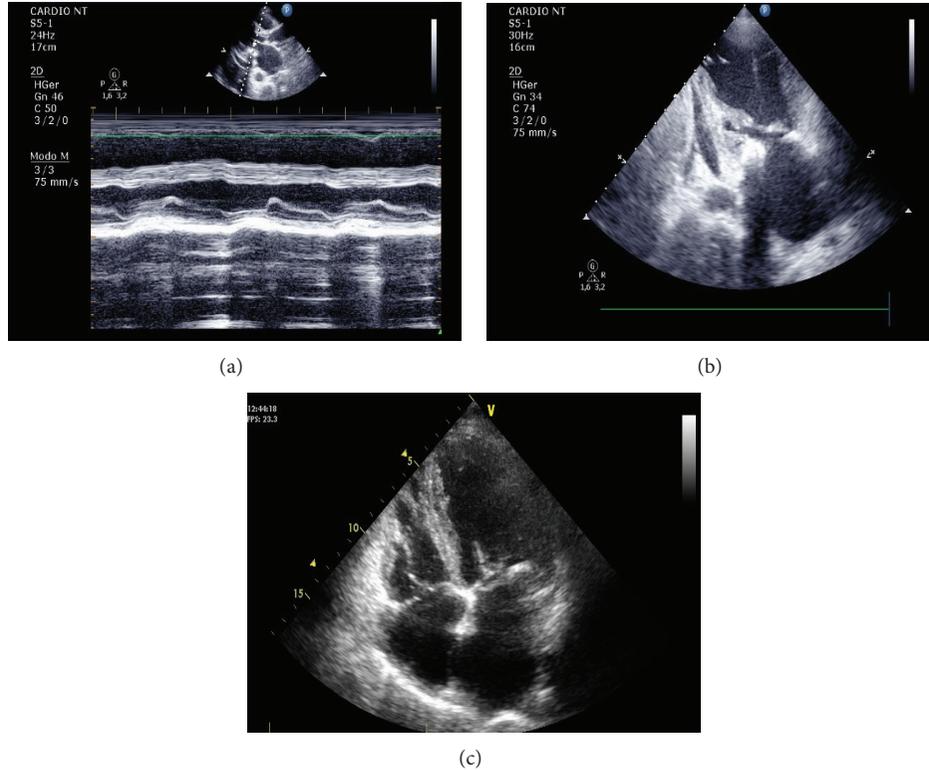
Echocardiographic findings: (a) parasternal incidence long axis, mitral valve M-mode, fibrotic leaflets, with limited leaflet excursion mobility, and annular calcification; (b) apical 2-chamber view, left LV, LA, mitral valve with fibrotic leaflet, and subvalvular apparatus and annular calcification; (c) apical 4-chamber view, LV, LA, RV, RA, mitral valve with fibrotic leaflet, and subvalvular apparatus and annular calcification.
